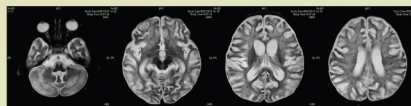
T2W. Serial MRI shows progressive atrophy of brain parenchyma with extensive white matter high signal.
